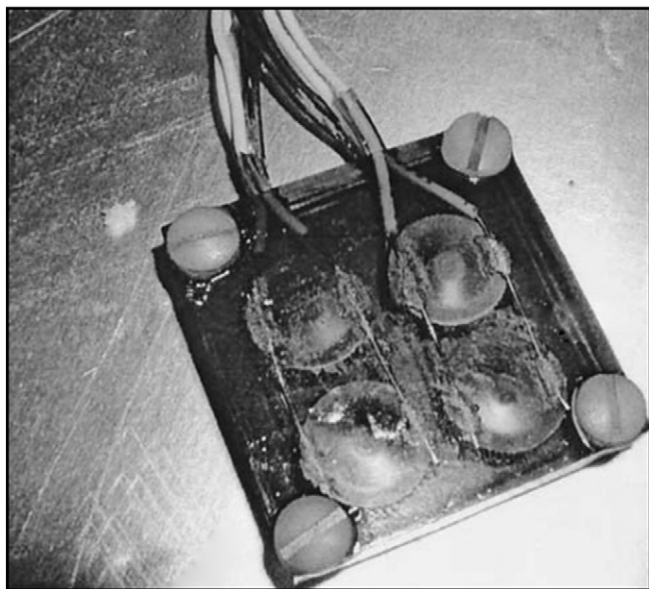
"Cymbal" array ultrasound device (dimensions $37 \times 37 \times 7 \text{ mm}^3$). Adapted with permission from [97].
